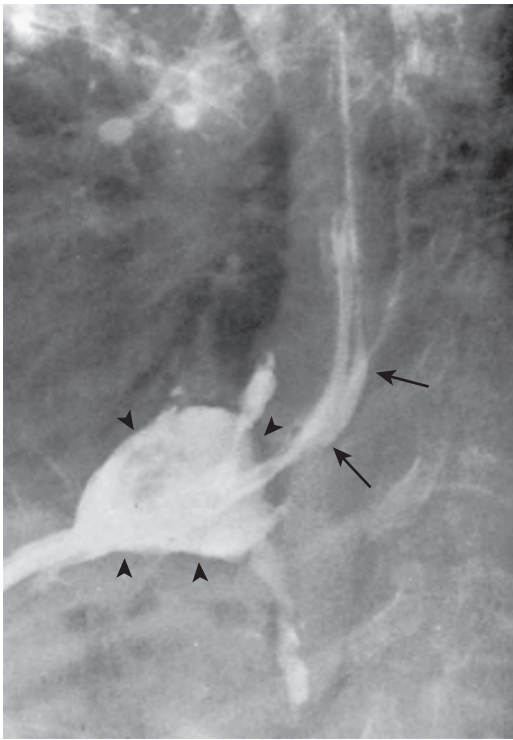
Percutaneous drainage of an esophageal leak. Sinography performed after CT-guided drainage of a juxtalesural fluid collection (arrowheads) shows communication with the esophagus (arrows).
